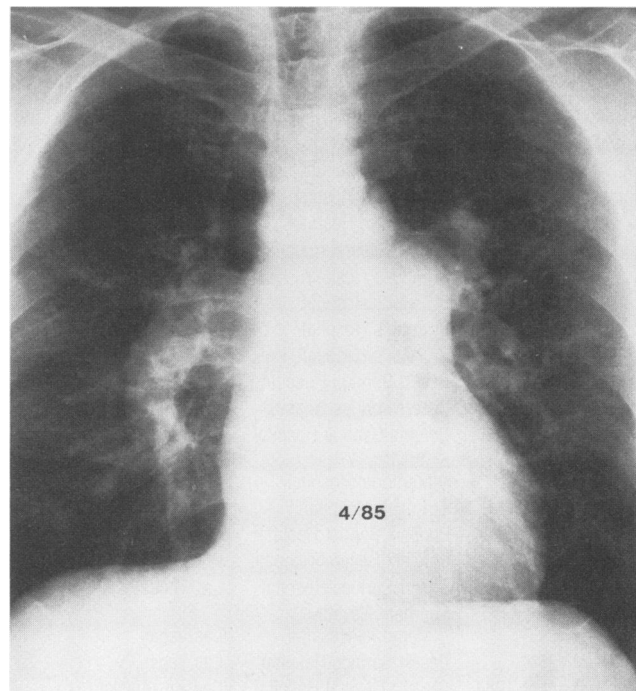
A chest roentgenogram shows enlarged main pulmonary arteries and cardiac silhouette.
